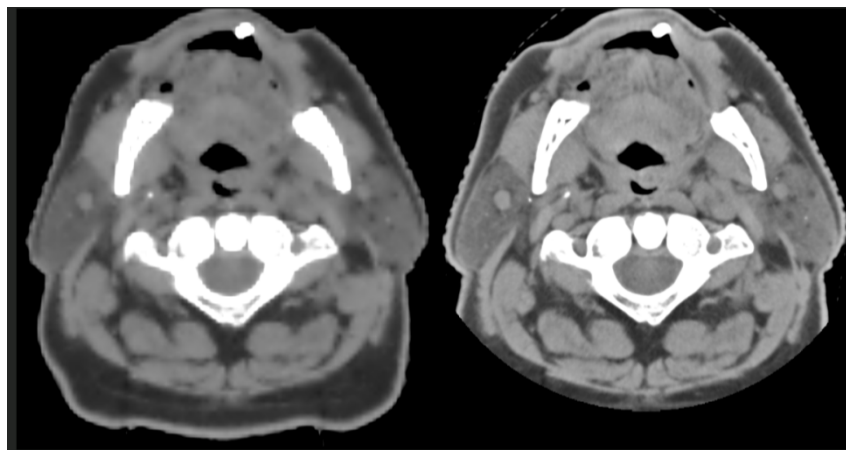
Images from a CT head and neck scan showing (left) the original 550 mm diameter reconstruction FOV and reconstruction kernel FC13 and (right) the improved image quality achieved by use of a 200 mm diameter reconstruction FOV and reconstruction kernel FC44.
